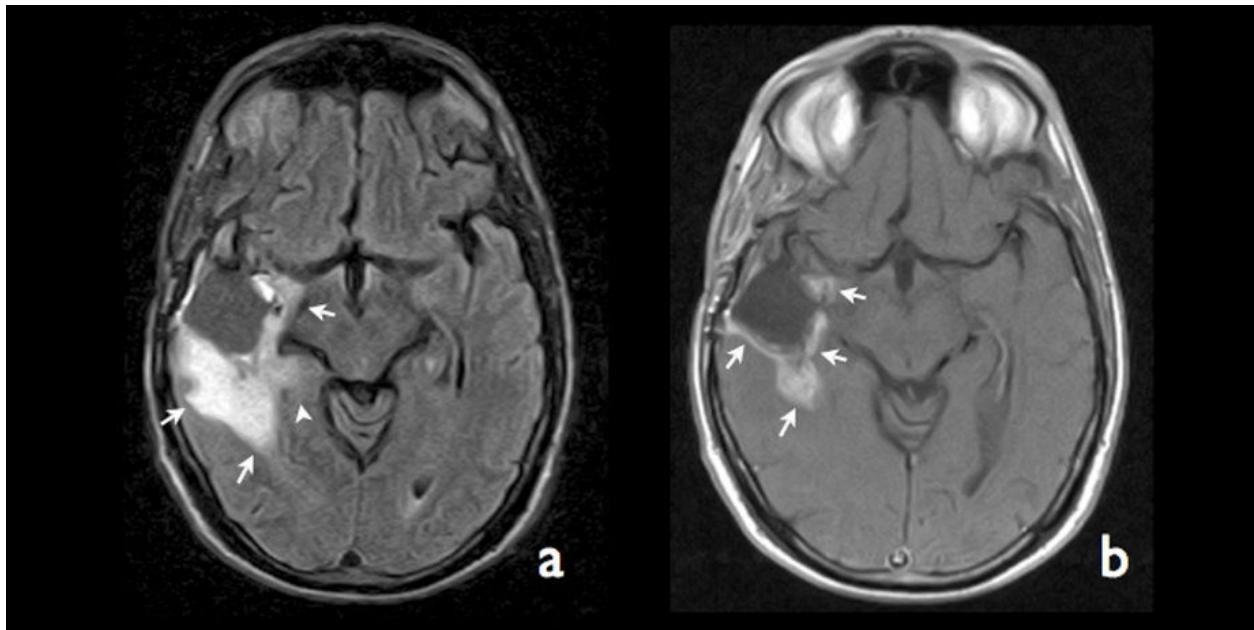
On FLAIR image (a), a thick irregular high-signal rim (arrows) was noted around the surgical margin with extension to the hippocampus (arrowhead). T1WI (b) showed linear enhancements around the surgical cavity and a nodule posteriorly (arrows).
